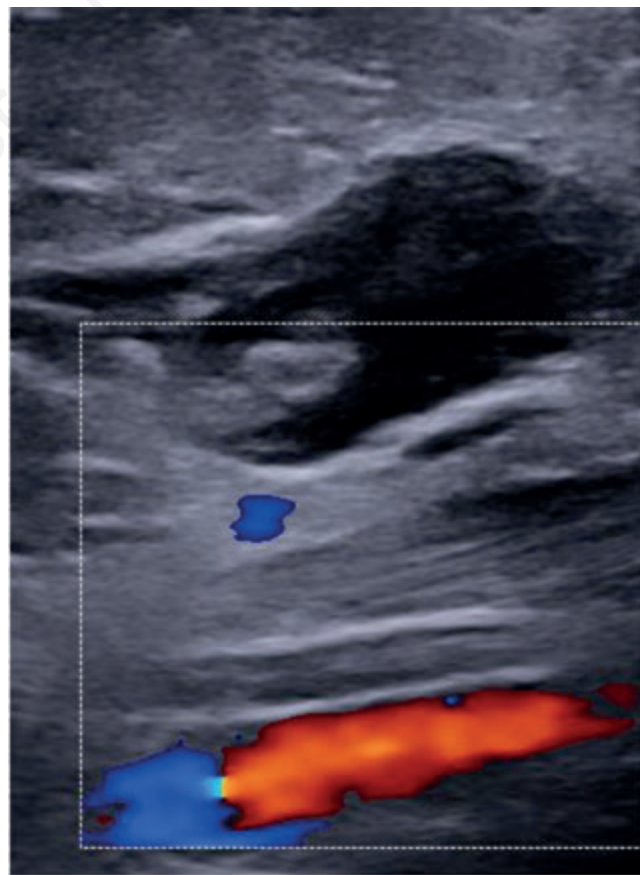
Image of the ultrasonographic exam of left upper limb demonstrating the presence of a nodular hypoechoic mass with irregular borders in the soft tissue, near the brachial vessels (red and blue signal in the color box).
